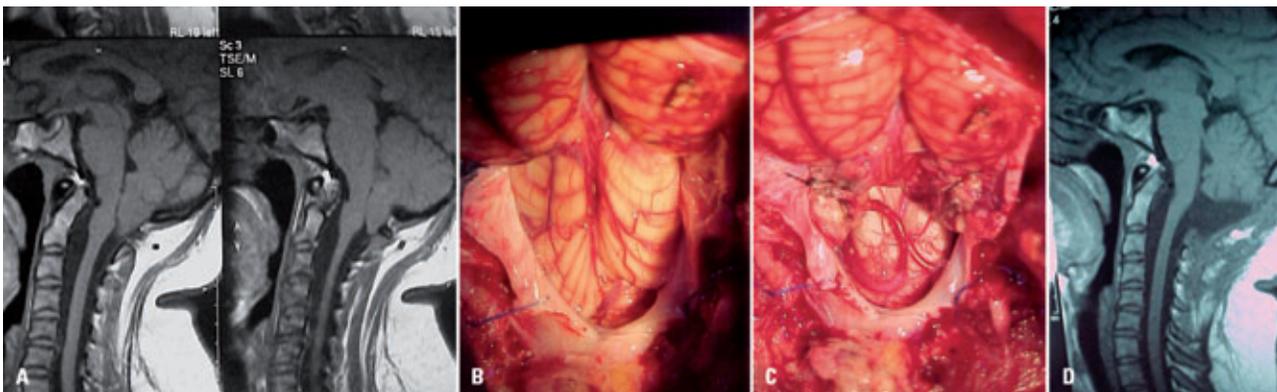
[A] Preoperative MRI depicting basilar impression (BI) and Chiari malformation (CM) at the level C1-C2. [B] More herniation of the cerebellar tonsils in the sitting position at the level of C3. [C] Tonsillectomy, large opening of the fourth ventricle and looping sign on the PICAS. [D] Postoperative MRI showing a large artificial cisterna magna.
